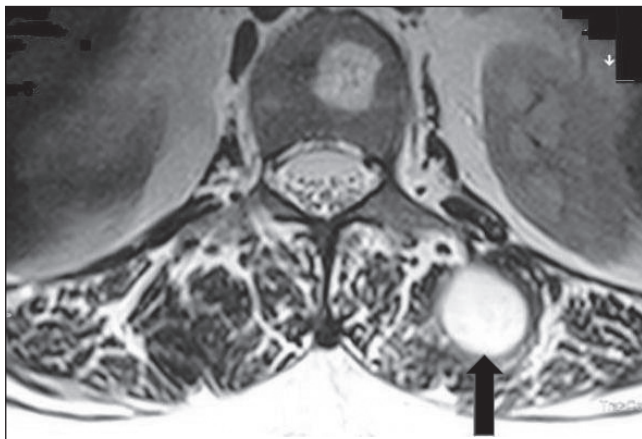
Magnetic resonance image of a patient (case 1) with pulmonary nocardiosis and dissemination to an abscess approximately 3.5 cm in diameter with thick wall (arrow) in the left lumbar muscle at level of L1 vertebral body caused by *Nocardia cyriaciageorgica*
